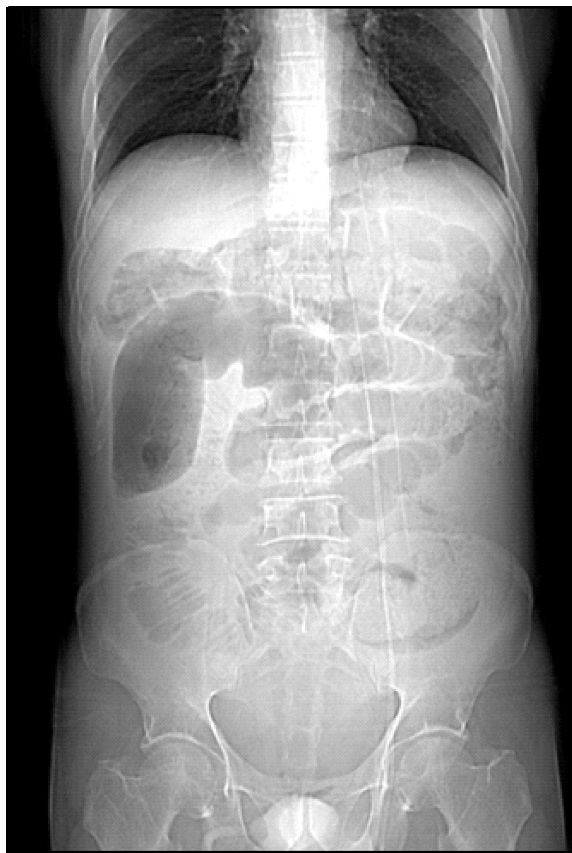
X-Ray abdomen showing dilated gut loops
